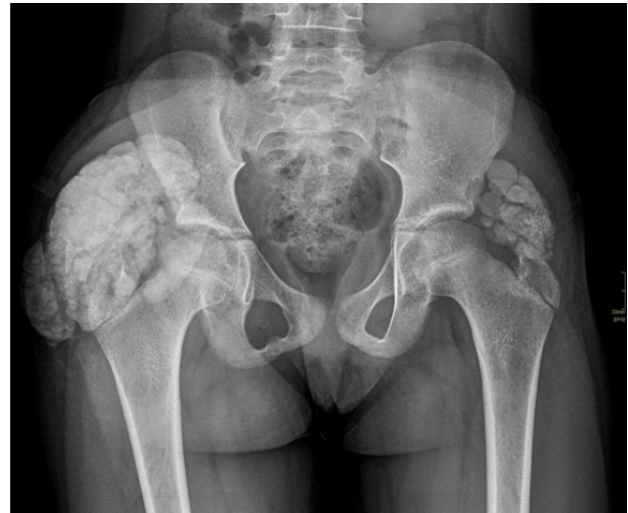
Preoperative Xray shows juxta articular bilateral Trochanteric lobulated, cystic, calcified mass.
